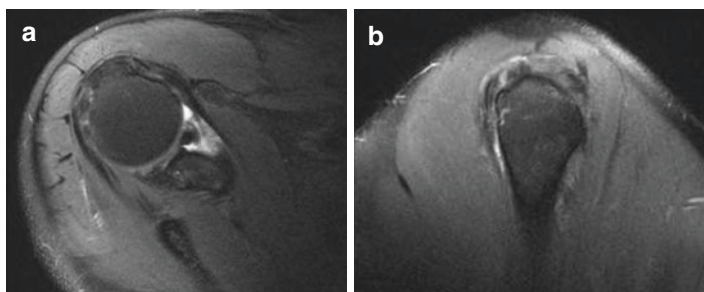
(a and b) The MRI shows undersurface signal of the labrum with a possible small recurrent tear as well as capsular effusion
